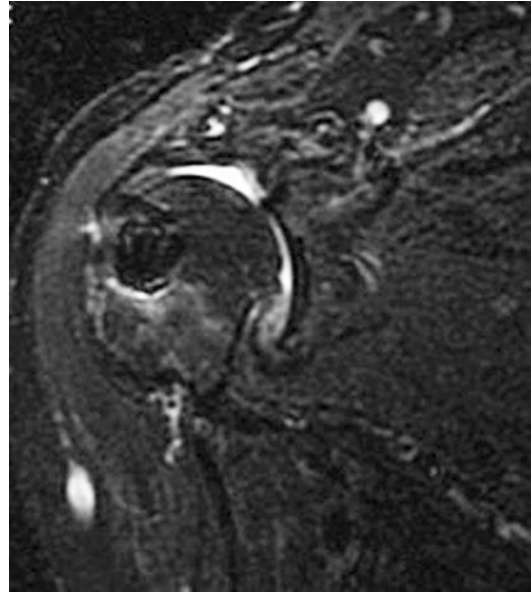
Right shoulder. Postoperative MRI (coronal view) shows healed rotator cuff (type 2 according to Sugaya's classification)
